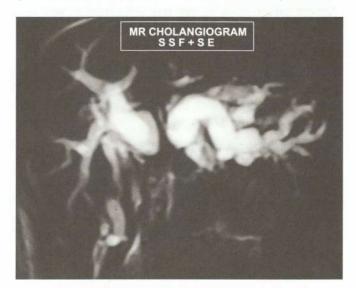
MRC intrahepatic dilatation, another case of cholangiocarcinoma—biopsy is not possible with MRI. Brush cytology is possible while doing ERCP
